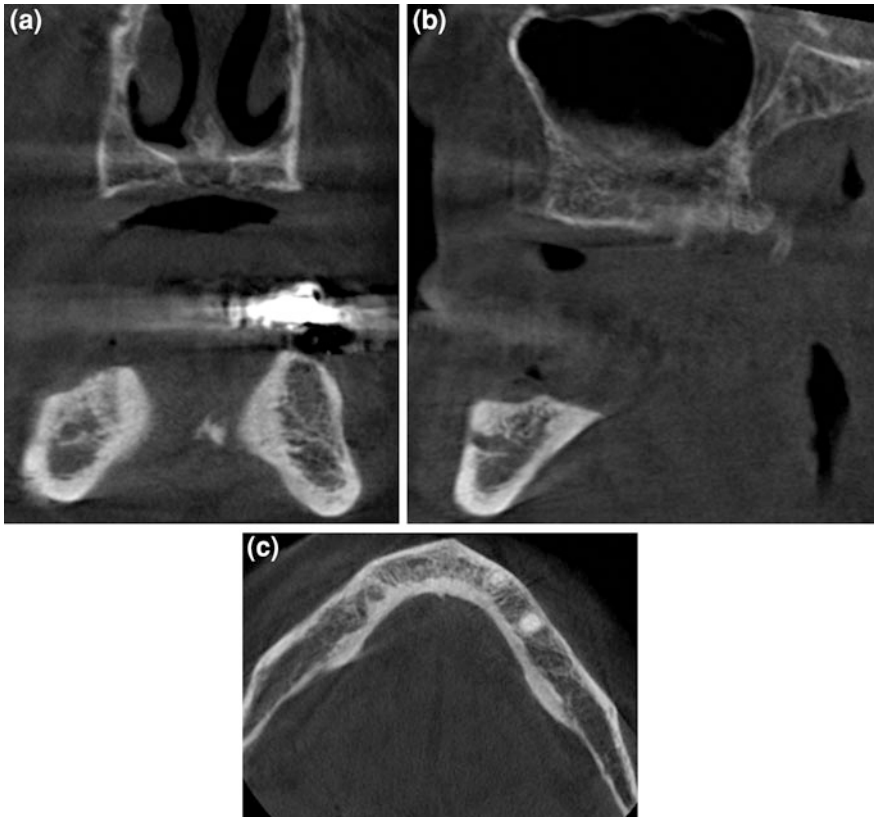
CBCT coronal (a), sagittal (b) and axial (c) sections in the area of missing mandibular teeth for planning implant
